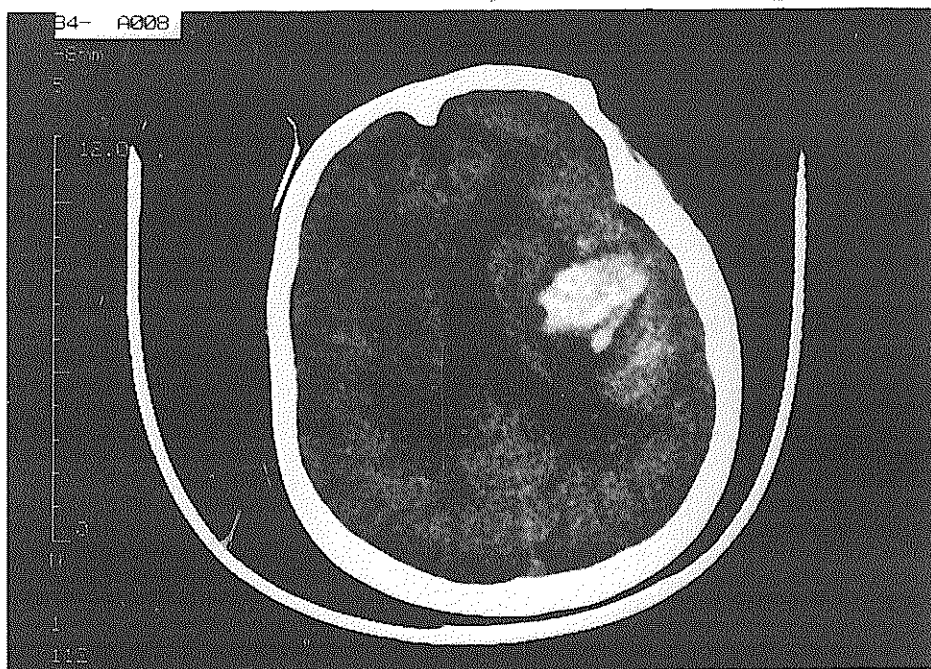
Noncontrast CT of patient 3 obtained at the day of onset: A hematoma in the left temporoparietal lobe.
